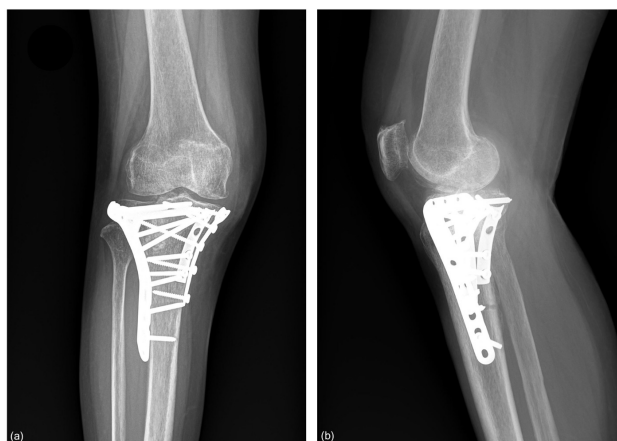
Post-operative radiographs of the right knee at 2-month follow-up demonstrating solid fracture union with bridging callus formation, maintained alignment, stable implant position, and no evidence of loosening or failure.
